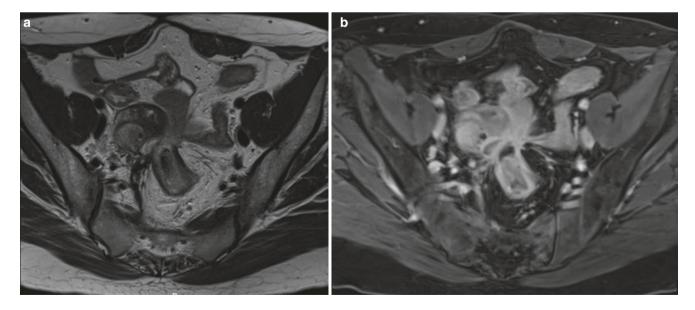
MR enterography demonstrating penetrating ileal disease with a complex stellate fistula involving the sigmoid colon on (a) T2-weighted and (b) post-gadolinium axial images
